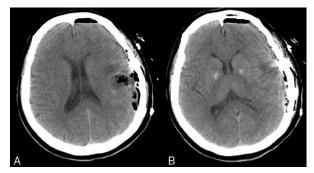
A-B, The postoperative CT scan of the patient. CT, computed tomography.
